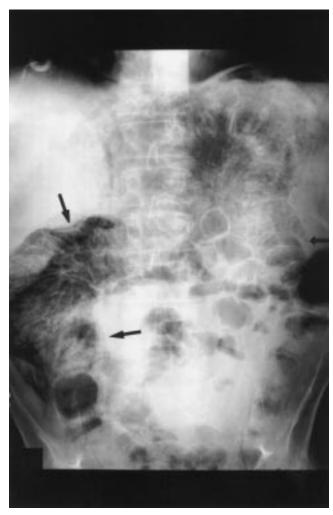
Plain abdominal radiograph performed on day +292 after transplantation showing intramural gas collections (arrows) suggestive for diffuse *Pneumatosis cystoides intestinalis*; in addition, free retroperitoneal gas is present.
